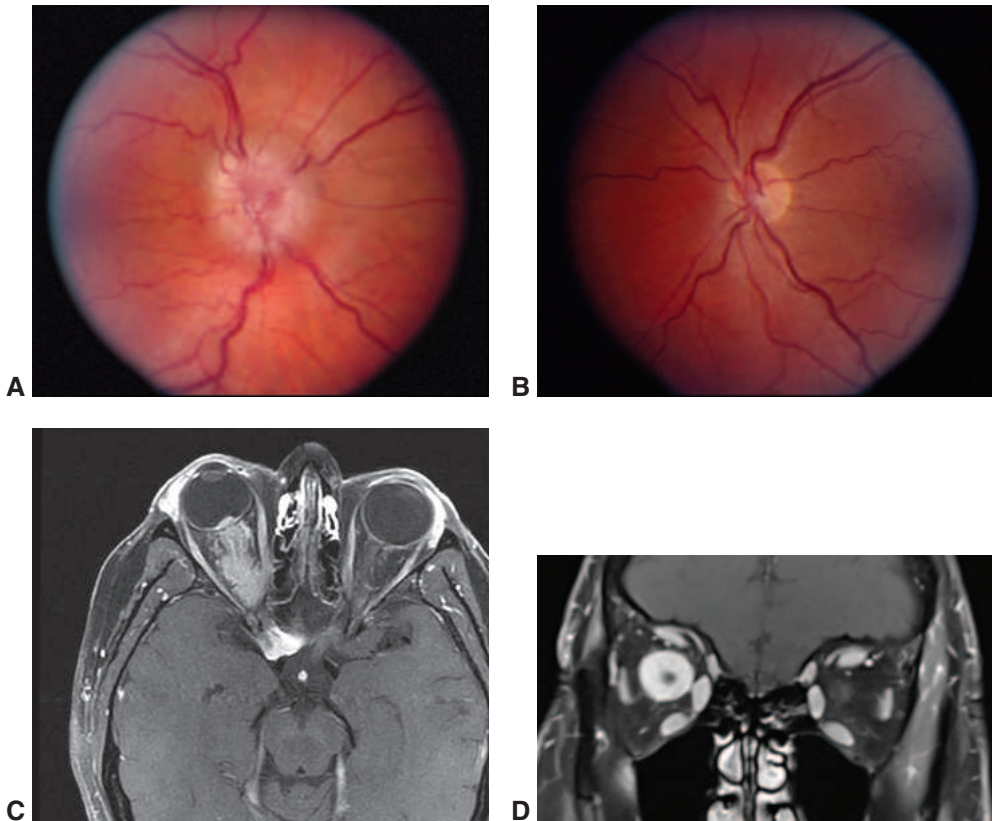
Optic nerve sheath meningioma. A, Swollen right optic nerve with tortuous arteries and dilated veins. B, Normal left optic nerve. Axial T1-weighted, gadolinium-enhanced MRI (C) and coronal contrast-enhanced (D) scans show optic nerve sheath meningioma. Note enlargement of the optic nerve sheath. (Parts A,B,C courtesy of Wayne Cornblath, MD; part D courtesy of Gregory Avey, MD.)
